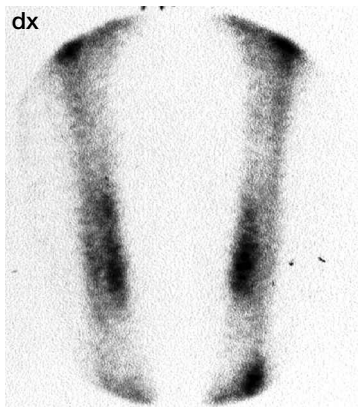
A 20-year-old male long distance runner who had mid tibial pain for several months. The radiographs were negative but scintigraphy shows bilateral bone stress injuries.
